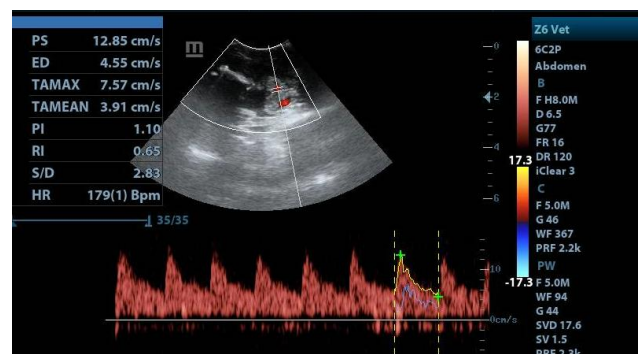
Postoperative 10th day doppler ultrasonography image of case 16
